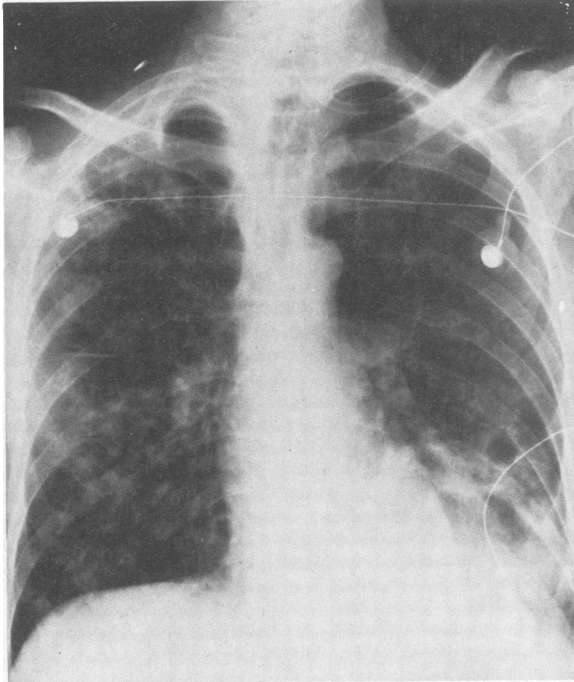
Roentgenogram of the chest, with the patient upright, on May 28, showing bilateral infiltrates with right upper and left lower lobe cavitation.
